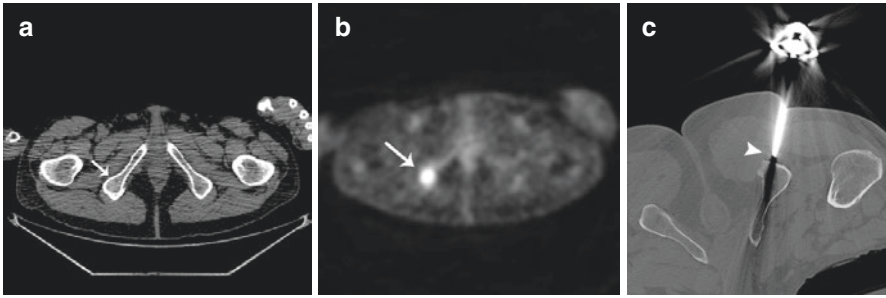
(a and b) PET/CT demonstrating a hypermetabolic bone lesion of the right ischium not visible on CT (*arrow*). (c) Nonreal-time PET/CT bone biopsy of the left ischium using co-registration of a prior PET image with a procedural CT image (*arrowhead*). Final diagnosis was ethmoidal carcinoma metastasis
